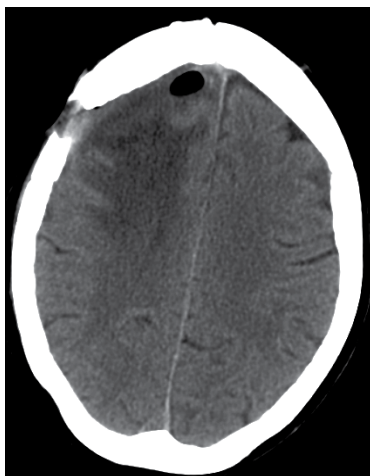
CT image of a right parasagittal anaplastic meningioma in a 69-year-old woman (same patient as in Figure 7, three years earlier)
